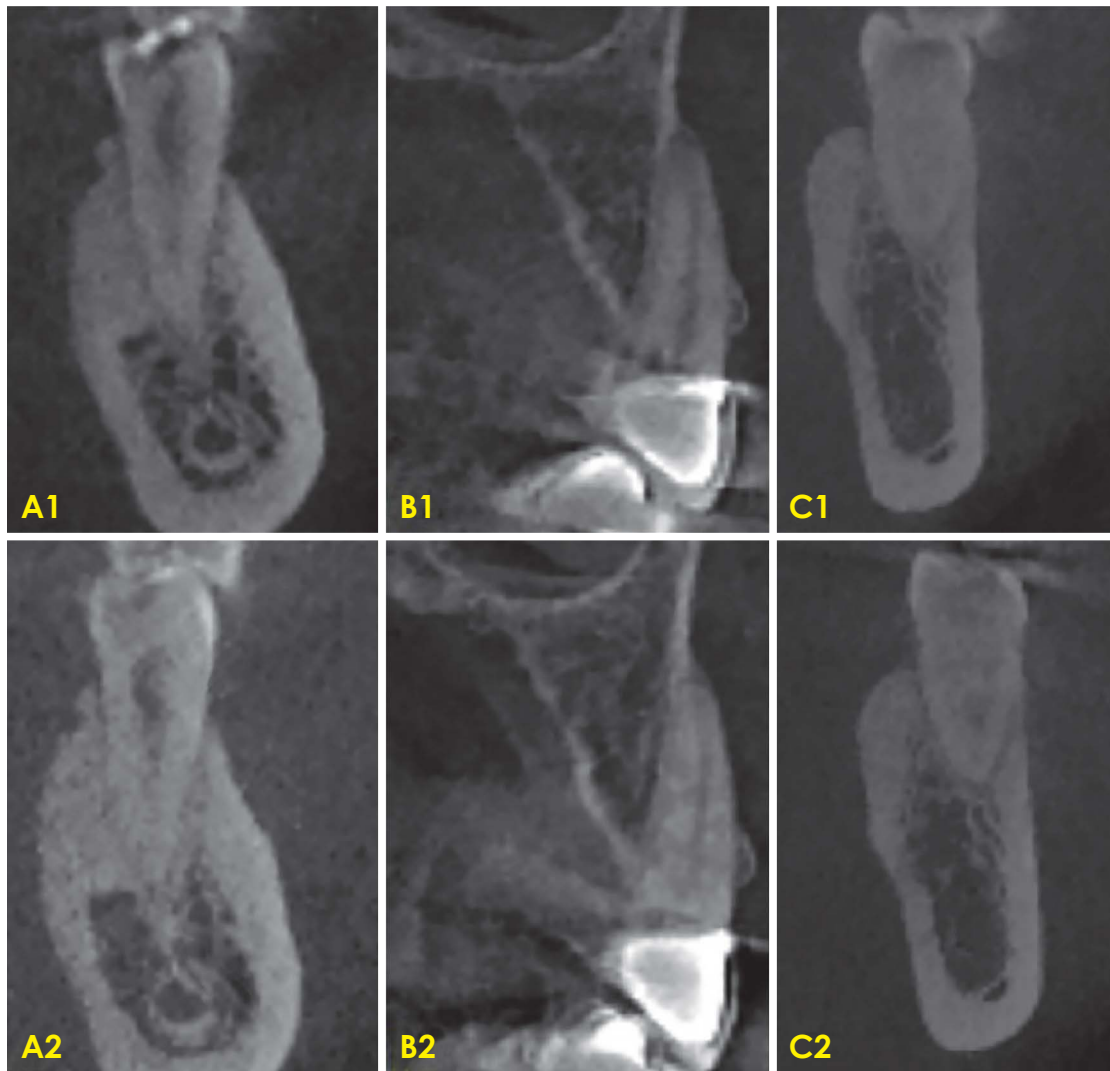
Cross-sectional cone-beam computed tomographic images show the similarities in image features, such as the teeth and surrounding structures used to generate similar slices for comparison of before and after surgery bone levels. A1 (pre-treatment) and A2 (post-treatment): similarities in the features of mental foramen and surrounding trabeculation bone pattern. B1 (pre-treatment) and B2 (post-treatment): similarities in features of the floor of maxillary sinus and restorations. C1 (pre-treatment) and C2 (post-treatment): similarities in the features of the trabeculation bone pattern and buccal/lingual cortices.
